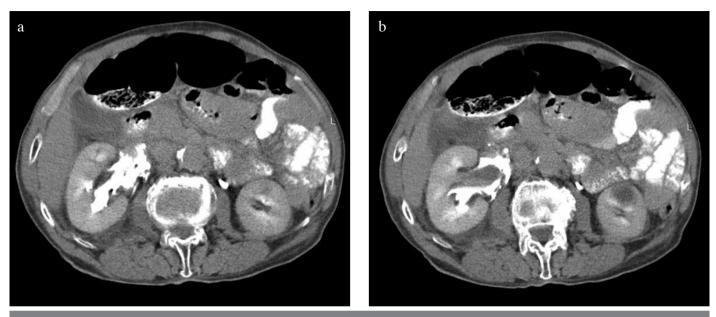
a, b. Delayed films of CT scan depicting contrast medium extravasation
